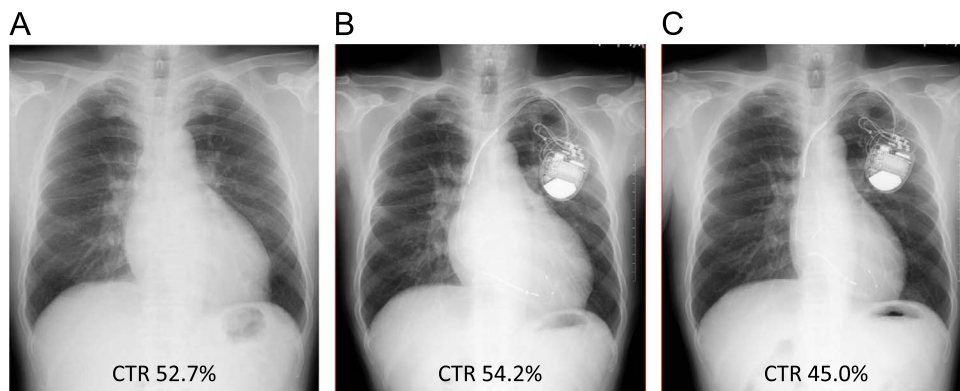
Chest X-ray. A: Before CRT. B: Four years after standard CRT. C: Nine months after adaptive CRT. CRT: cardiac resynchronization therapy.
